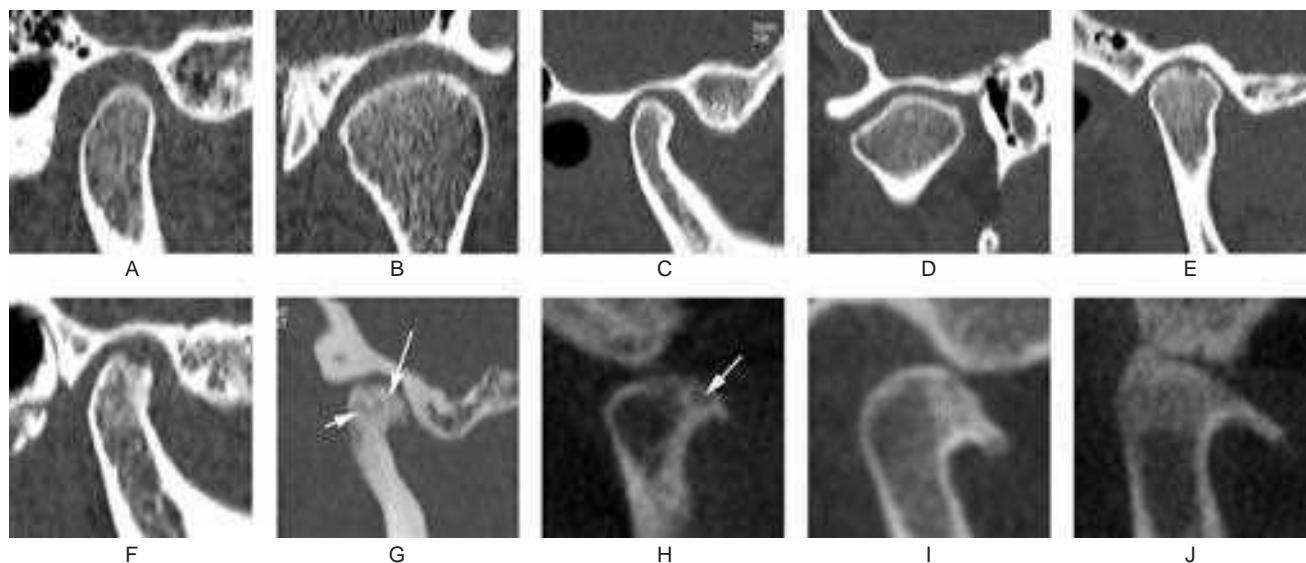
Computed tomographic findings of normal and osteoarthritic temporomandibular joints.
